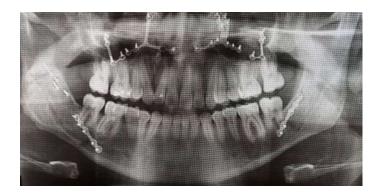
Panoramic radiograph after 8 years of the surgical procedure.
